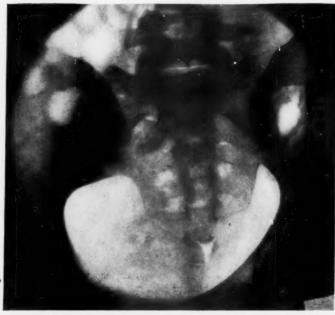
(Case 1.) Postoperative roentgenogram showing operative window through illum and sacrum at sacro-illiac joint.
